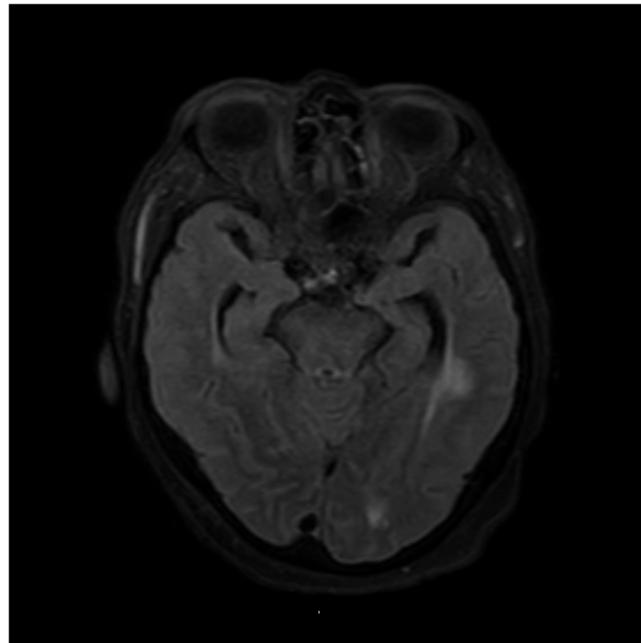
MRI Brain T2W FLAIR showing decrease in the edema. Abbreviations: FLAIR, fluid attenuated inversion recovery; MRI, magnetic resonance imaging.
